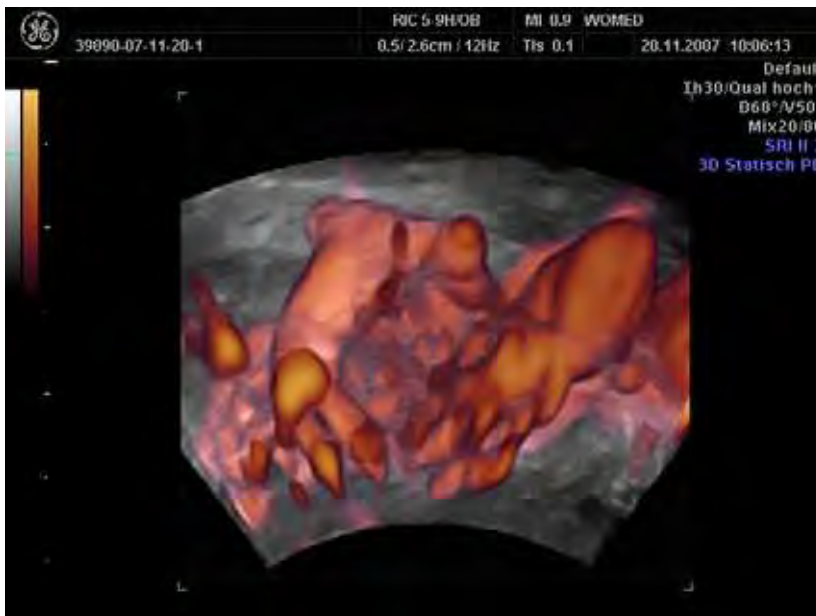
Case 2. Chronic recurrent thyroiditis in 3-D power Doppler modus using a vaginal transducer. Note the increased vascularity as compared to Figure. 3
